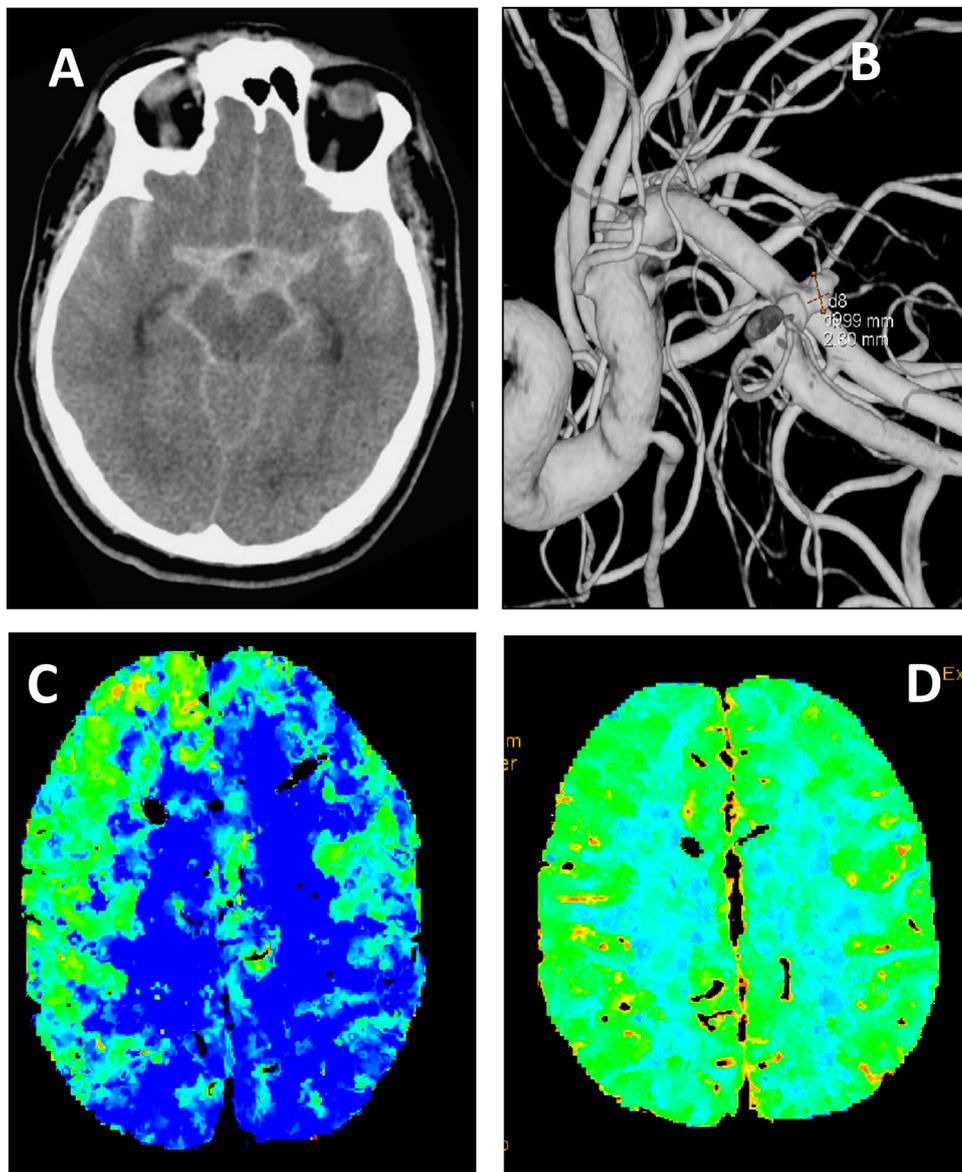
Initial CT scan showing a diffuse haemorrhagic pattern involving the ventricular system classified grade IV in the Fisher Scale (A) secondary to the rupture of a 3 mm aneurysm of the anterior communicating artery (B). Secondary CT scan with perfusion sequences showing vasospasm in anterior cerebral arteries (Tmax sequences: C) without constituted ischemia (cerebral blood volume sequences: D).
